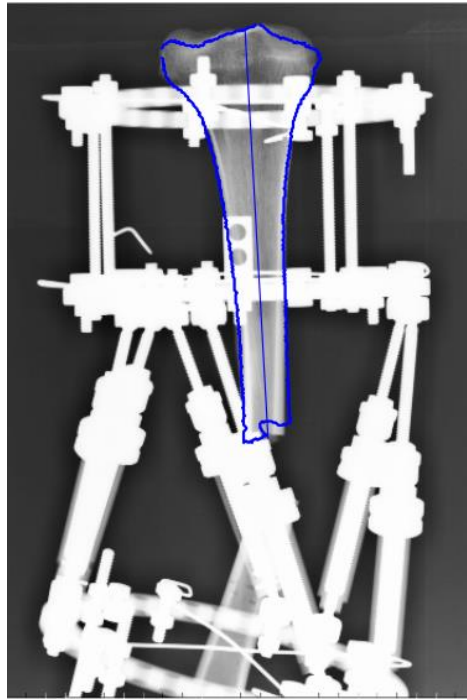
Result of the bone alignment process. The contour and center line obtained from pre-operation X-ray image is drawn on the fixator system image after alignment process (blue line).
